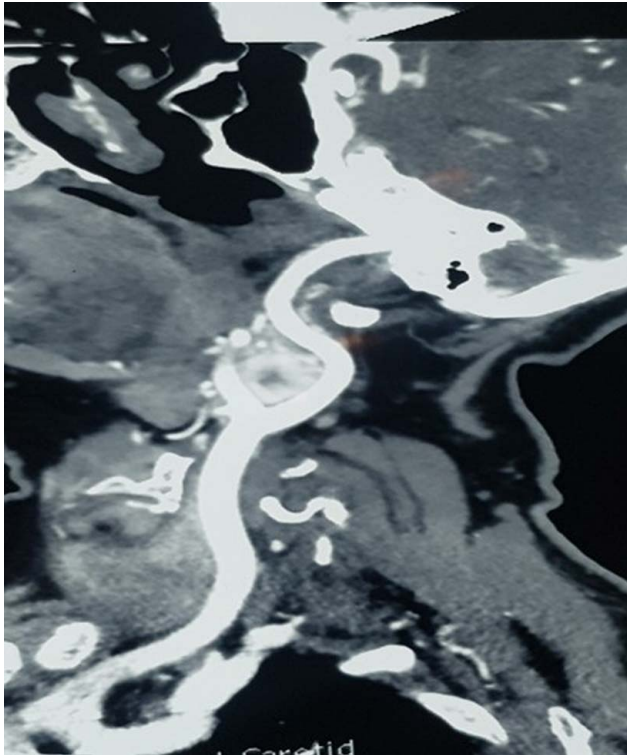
Computed tomographic angiography of the carotid bifurcation shows a large carotid body tumour.
